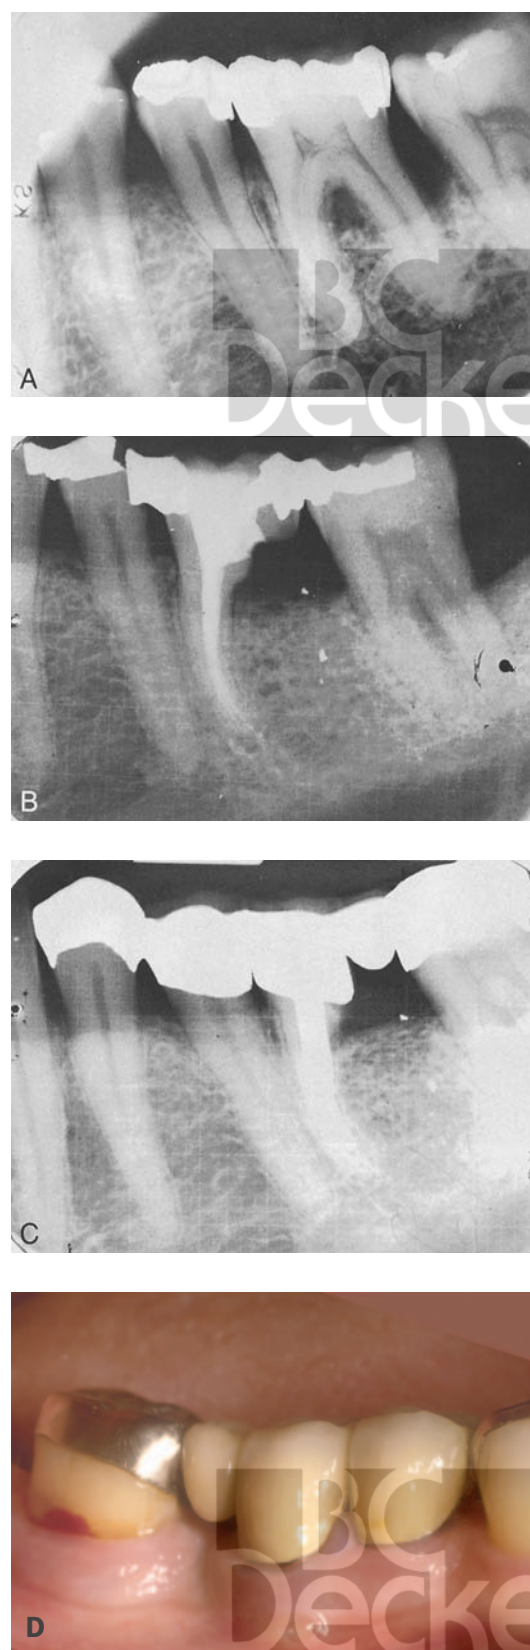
Mandibular hemisection. A, Pretreatment x-ray study showing severe involvement of the distal root. B, Hemisection completed. C and D, Six years later, the restoration is complete and bone has filled in about the remaining root. Prosthetics courtesy of Dr. William Irving, Needham, MA.
